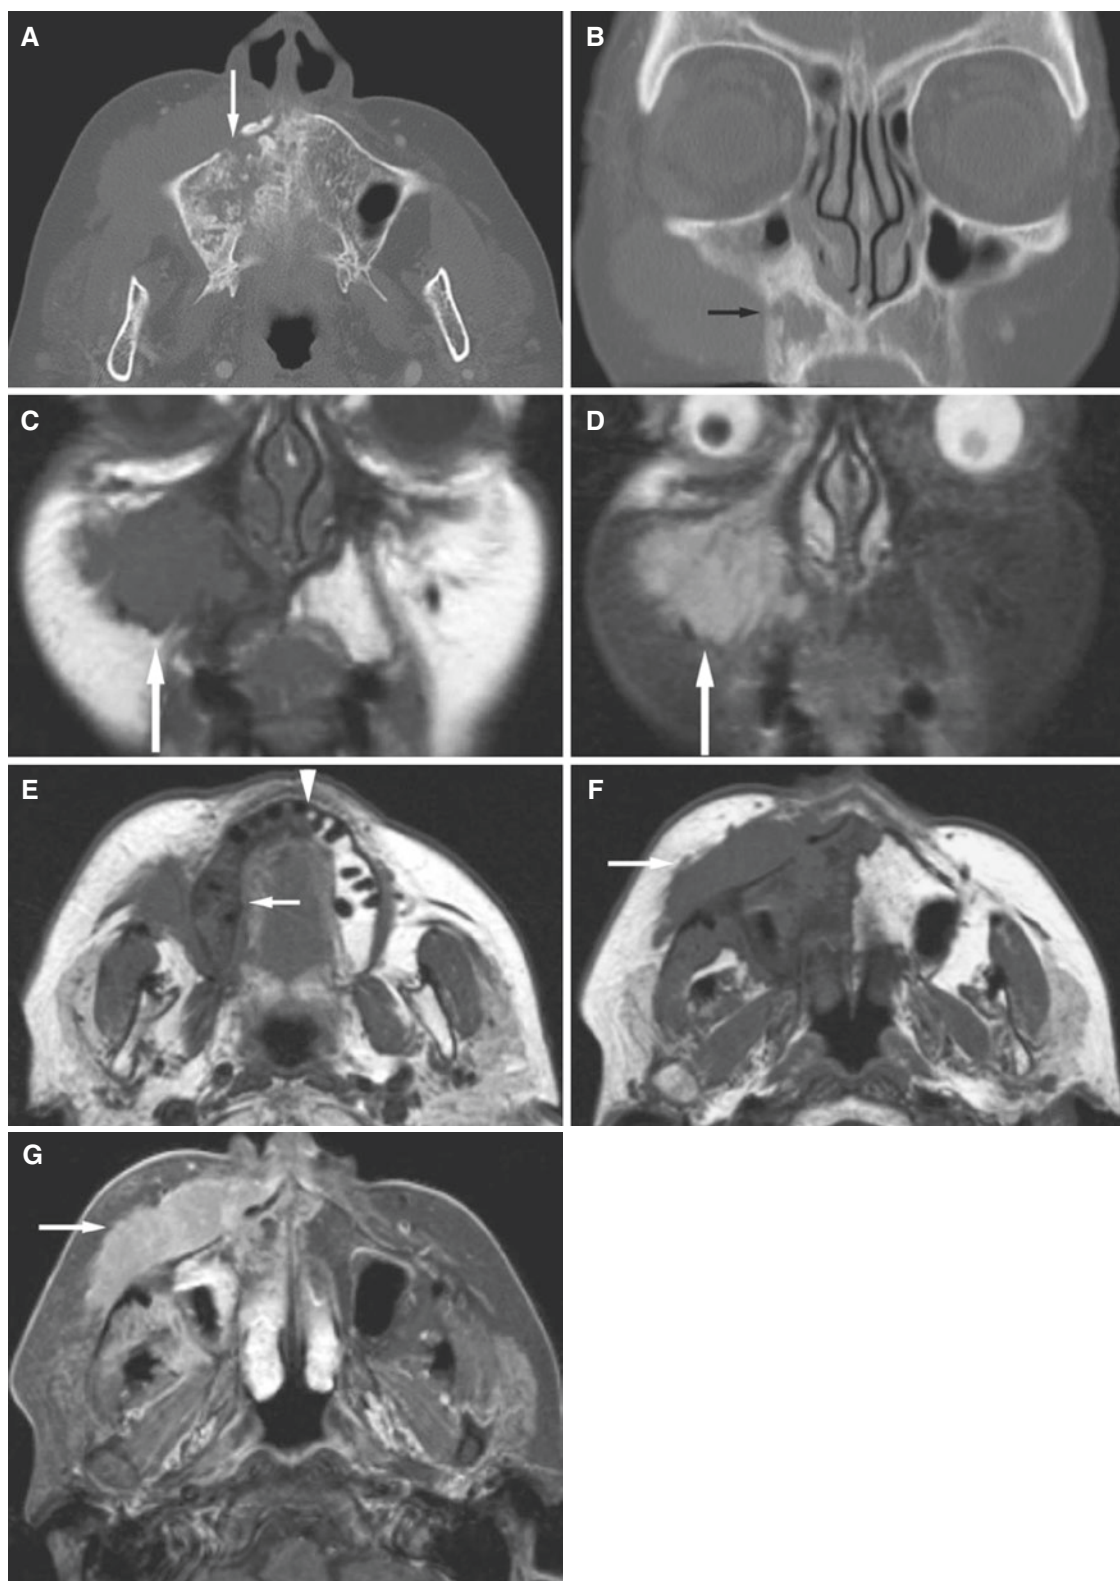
B-cell lymphoma, maxilla; 74-year-old female with painless swelling of the cheek. (A) Axial CT image shows ill-defined bone destruction of the palate (*arrow*). (B) Coronal CT image shows ill-defined bone destruction of the alveolar bone (*arrow*). (C) Coronal T1-weighted pre-Gd MRI shows intermediate-low-signal tumor in bone marrow (*arrow*). (D) Coronal STIR MRI shows intermediate-high-signal tumor (*arrow*). (E) Axial T1-weighted pre-Gd MRI shows
